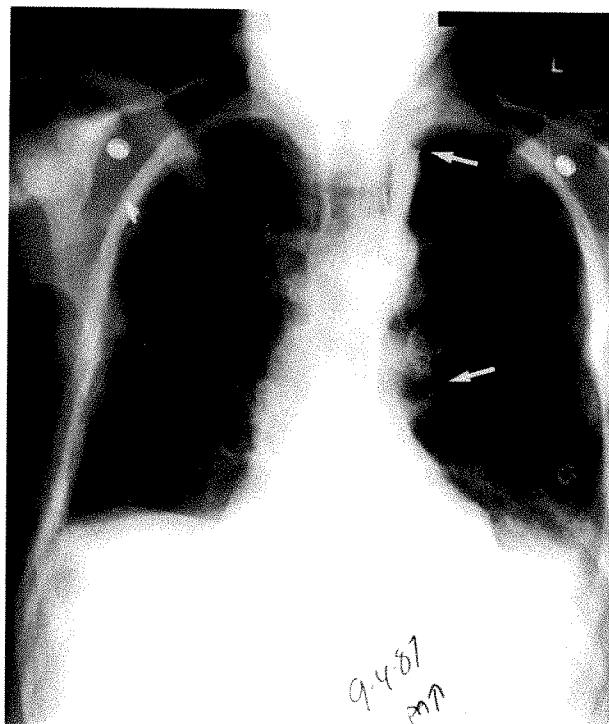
Chest x-ray (PA view) with arrows showing the margins of spread of contrast following injection of contrast medium through the catheter. Note the paravertebral location with spread between the T3-T8 vertebral bodies.
